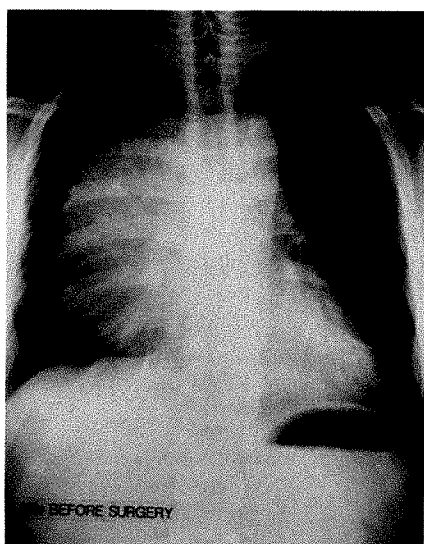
Chest roentgenogram showing large mediastinal tumor 1 mo before surgery.
